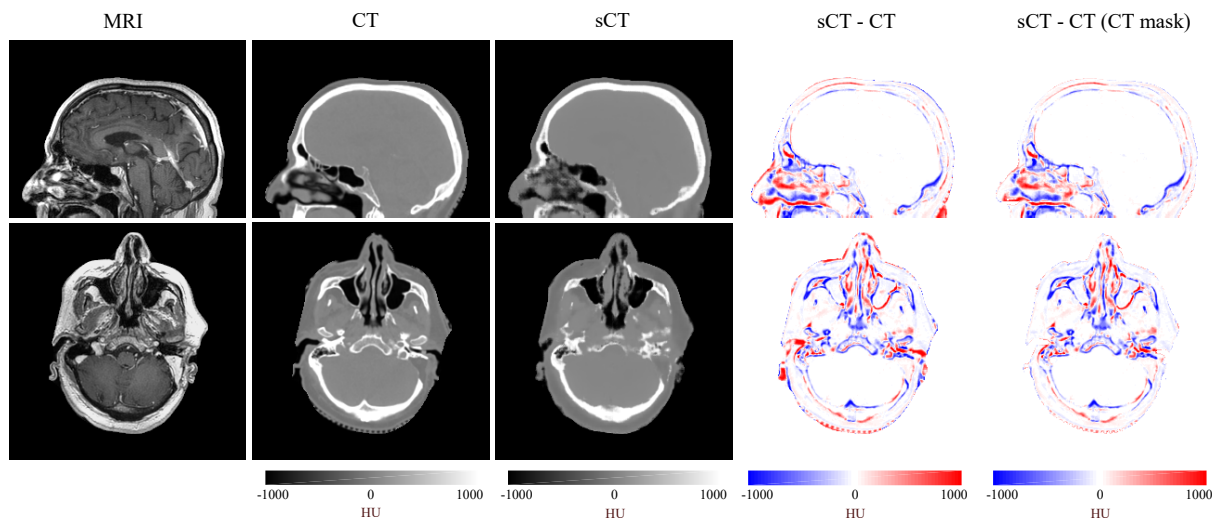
Sagittal and axial views of MRI, CT, synthetic-CT and corresponding difference maps based on the MRI body mask and on the CT body mask for a patient with suboptimal registration.
